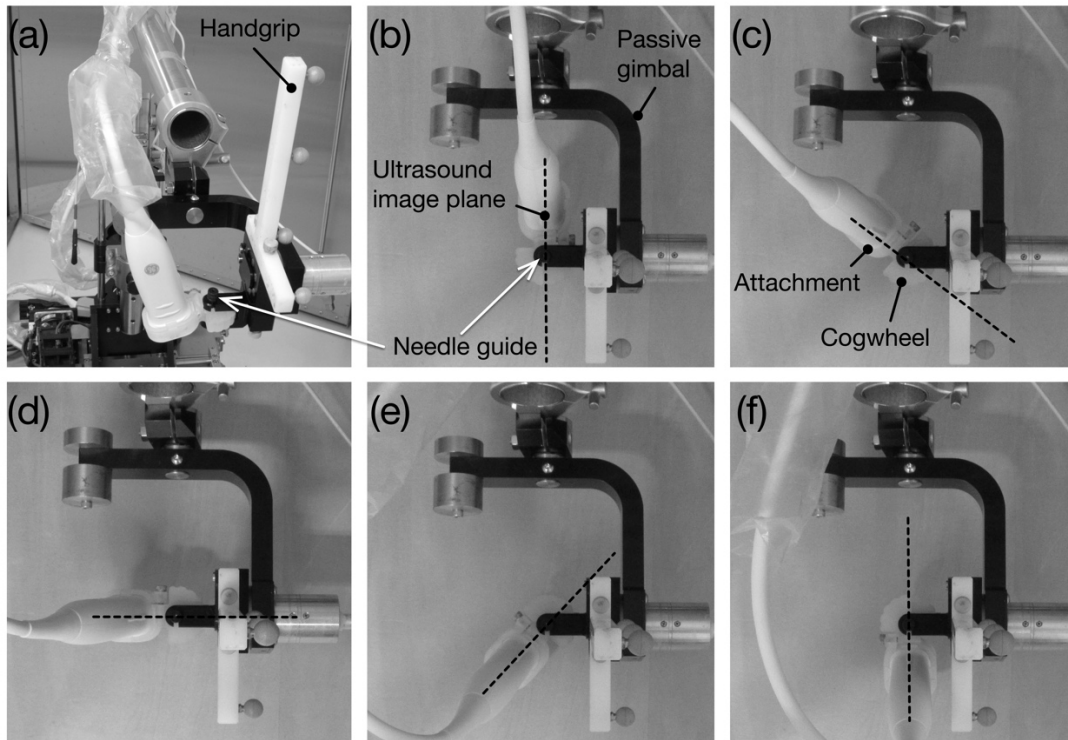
Needle manipulator passive end effector: (a) overview, and (b)–(f) top views. The installed ultrasound (US) probe could be rotated 180° around the needle guide positioned at the intersection of the two passive gimbal rotational axes. The passive gimbal provided sufficient space for the US probe to be rotated. White solid arrows represent needle guide locations and dotted lines represent the US imaging plane.
